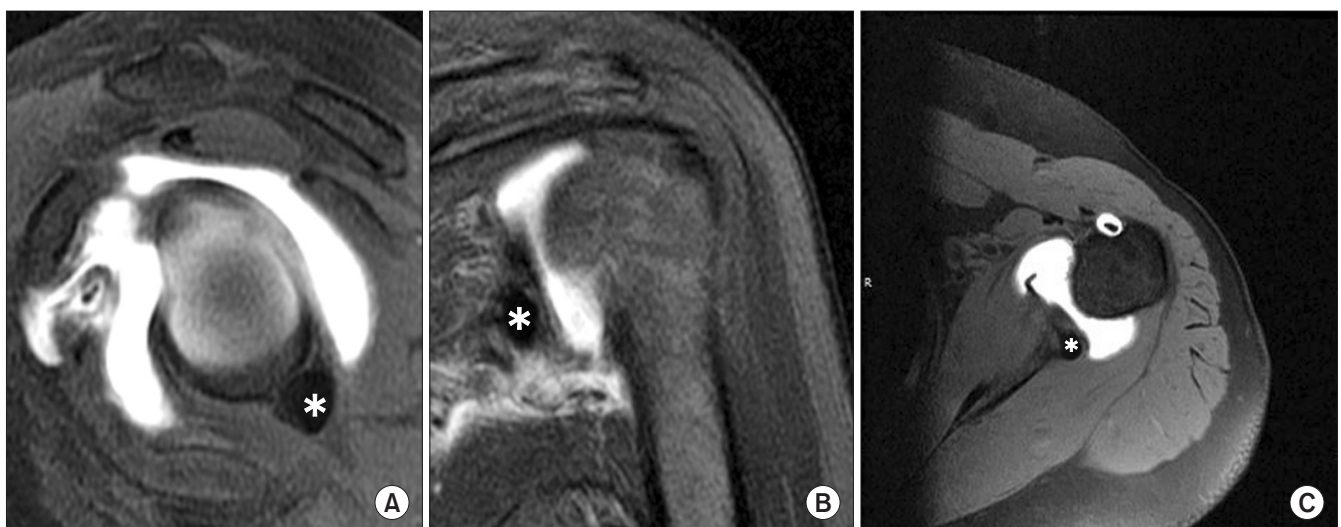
Magnetic resonance arthrography, (A) T1-weighted sequence coronal image, (B) T2-weighted sequence sagittal image, (C) T1-weighted sequence axial image shows decreased signal intensity corresponding with the calcification (asterisks) at the origin of the long head of the triceps.
